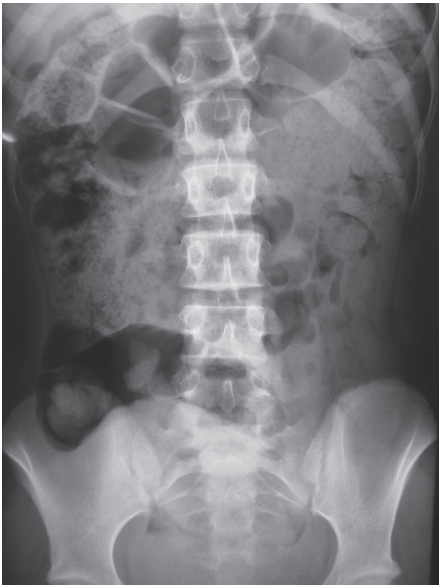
Abdominal radiograph of a young woman with chronic constipation, demonstrating severe faecal loading of the colon.
